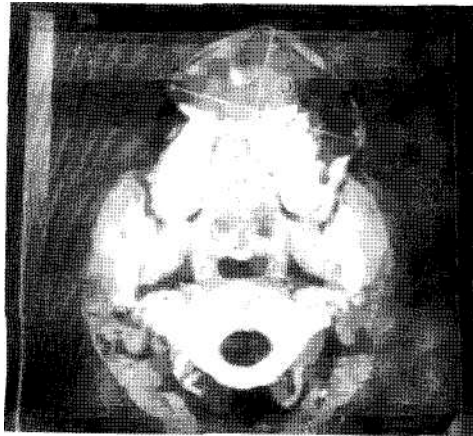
Photograph of CT scan showing sublabial extension of the growth to opposite antrum ( Axial view).
